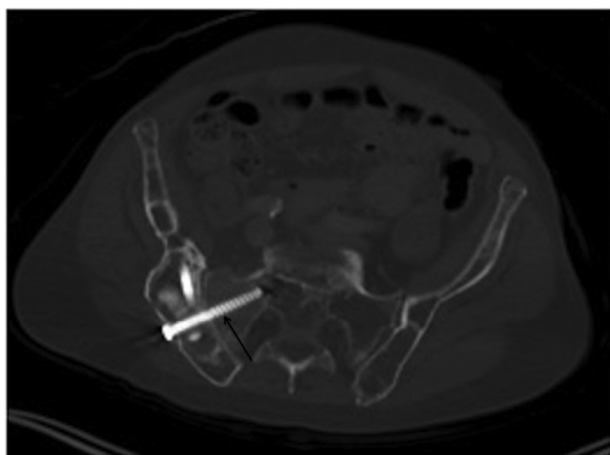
(Patient 2) Axial-oblique reformatted computed tomography image shows a 50 mm long x 6.5 mm wide screw (arrow) across the upper sacroiliac joint crossing the lytic cavity in the iliac bone and a ground glass portion in the sacral ala. Just over half the screw length is embedded in the more solid sacral wing, conferring better joint fixation stability than in patient 1.
